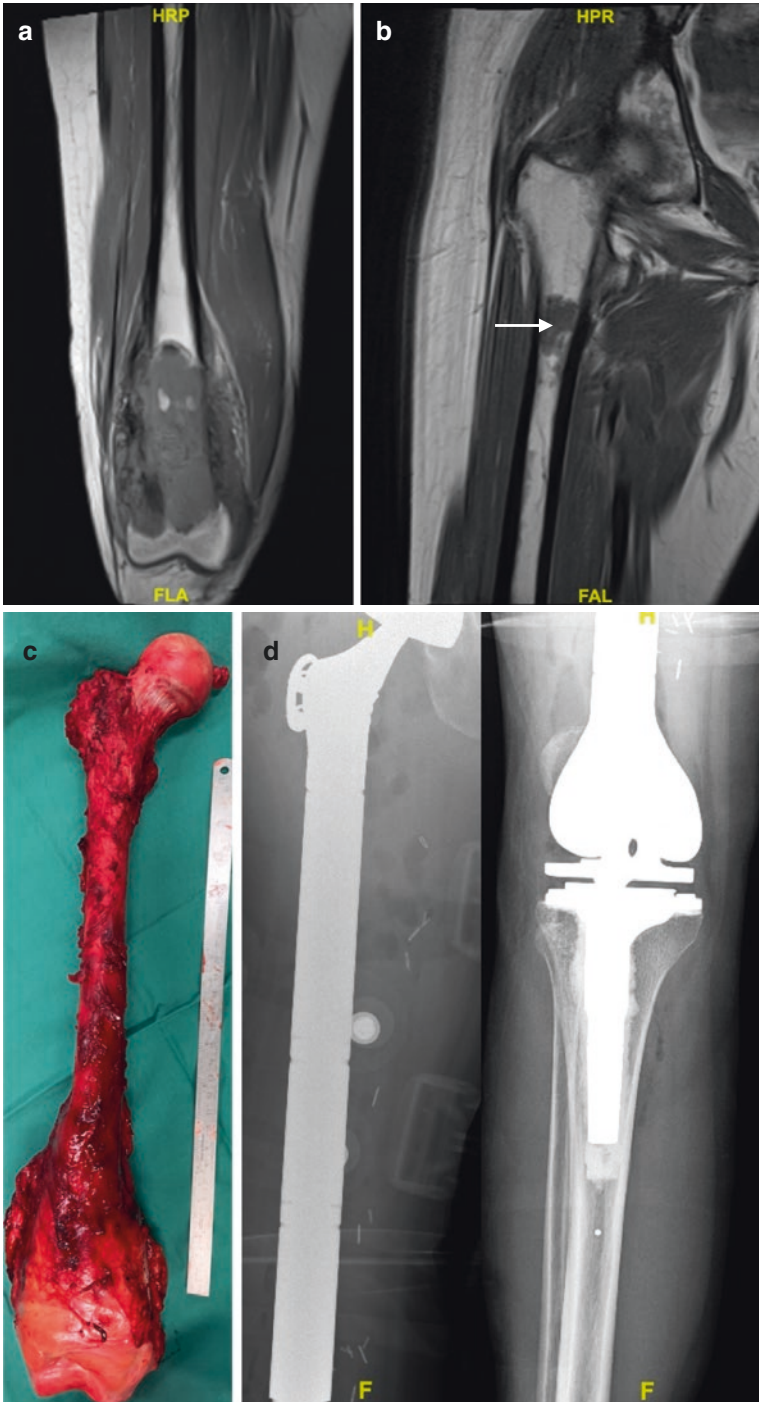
T1-weighted coronal MRI images of (a) distal femoral tumour and (b) proximal skip lesion (arrow). This tumour was treated with (c) total femoral resection and (d) reconstruction with a total femoral tumour endoprosthesis
